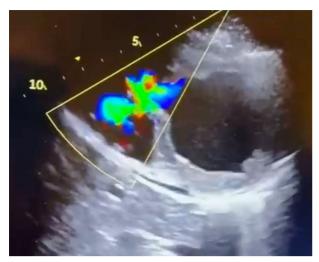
Transthoracic echocardiography imaging during percutaneous coronary intervention.
